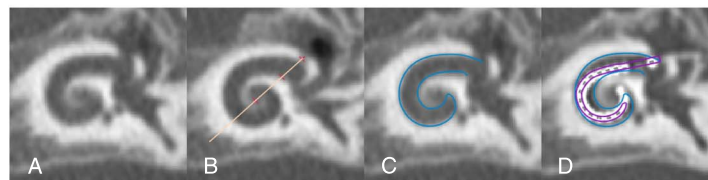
Analysis steps using the radiological tool. A, Crop and realign CT to cochlear view. B, Place anatomical landmarks, C, Generate cochlea 3D model; D, Generate electrode model from spatially synchronized postoperative CT indicates computed tomography.
